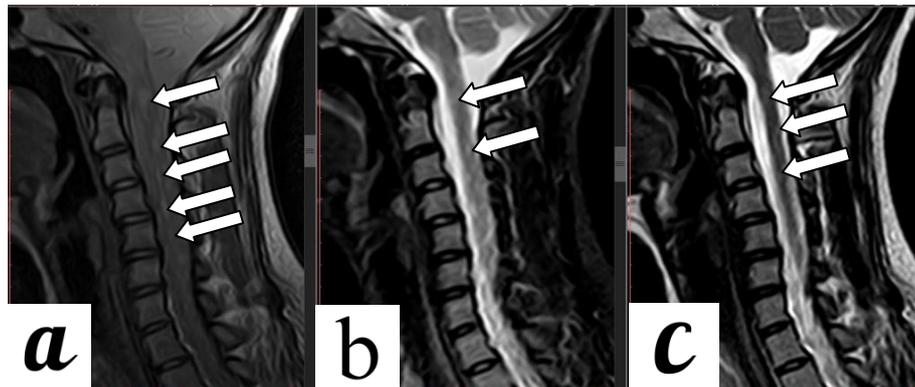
20 Yrs female cervical MRI multiple tiny lesions noted at PD(a) while STIR shows only 2 lesions (arrows at b) and three lesions at T2(c).
